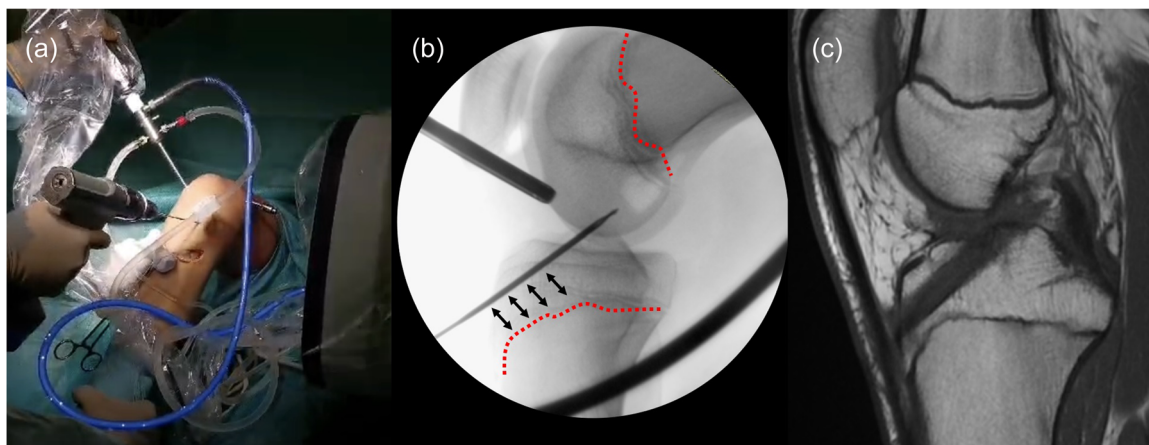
Setting for supra-physal tunnel preparation, with the knee at 90° of flexion and the C-arm perpendicular to the lower limb (a). Intra-operative lateral x-ray shows the placement of the k-wire above the tibial growth plate (red dotted line) and within the proximal tibia epiphysis (b). Post-operative MRI shows no conflict of the tibial tunnel with the tibial growth plate (c). MRI, magnetic resonance imaging.
